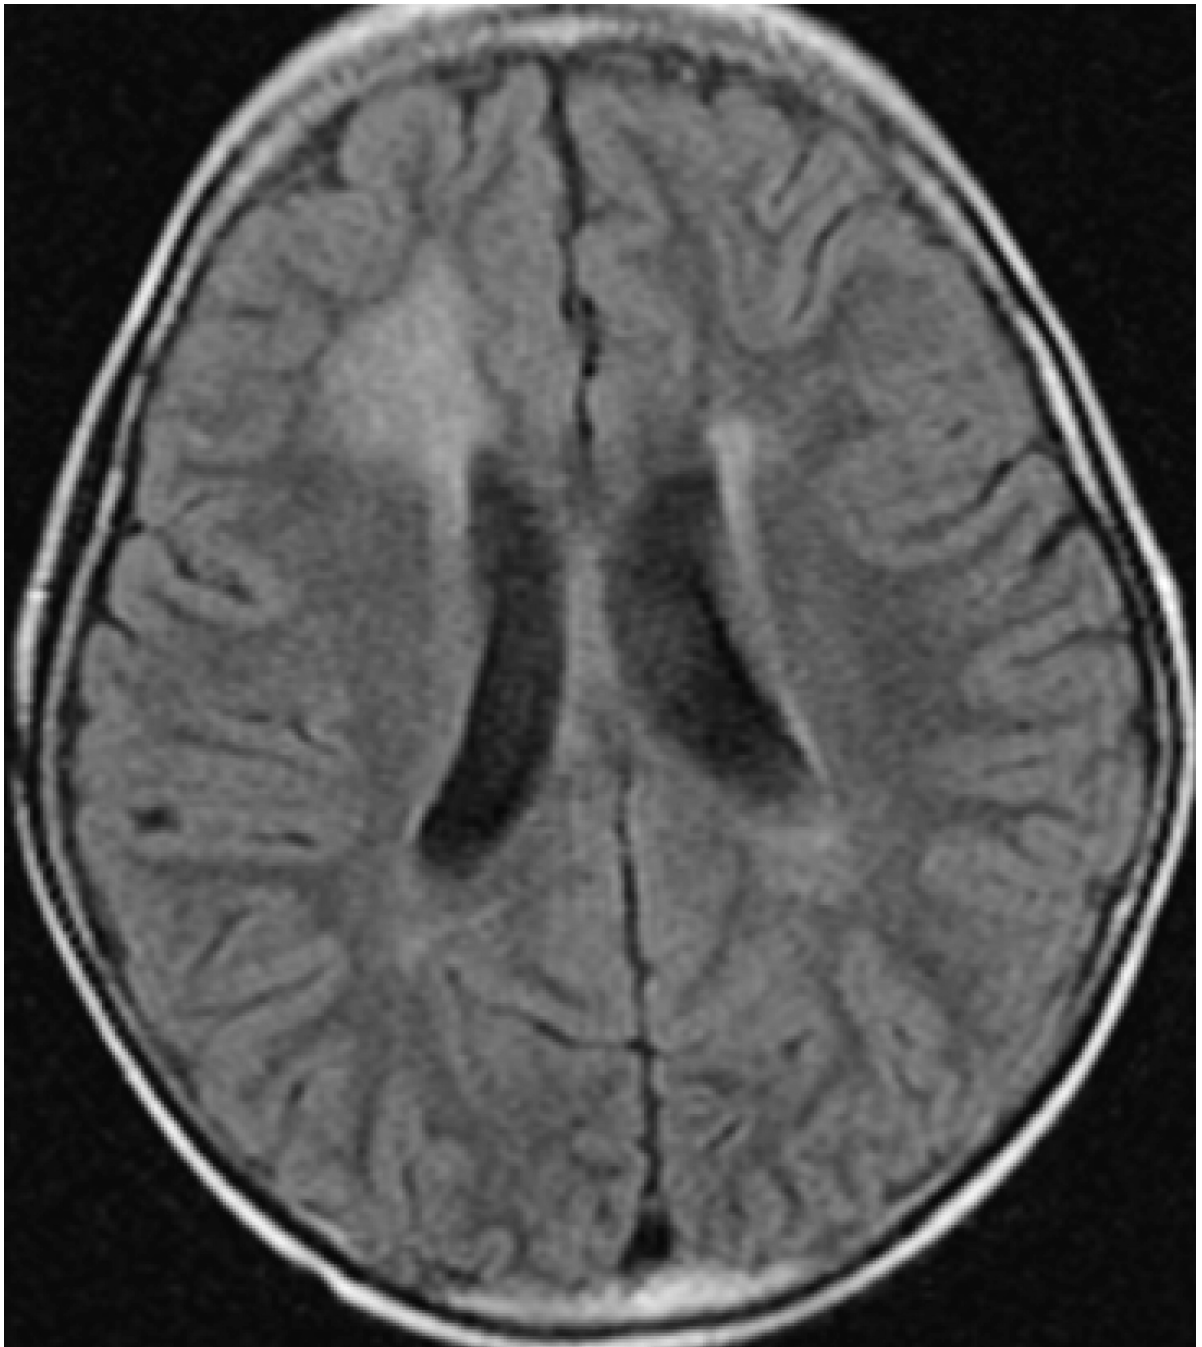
Axial Fluid Attenuation Inversion Recovery (FLAIR) image demonstrate the increased signal in predominately right frontal lobe in a patient with radiation injury sceondary to irradiation.
